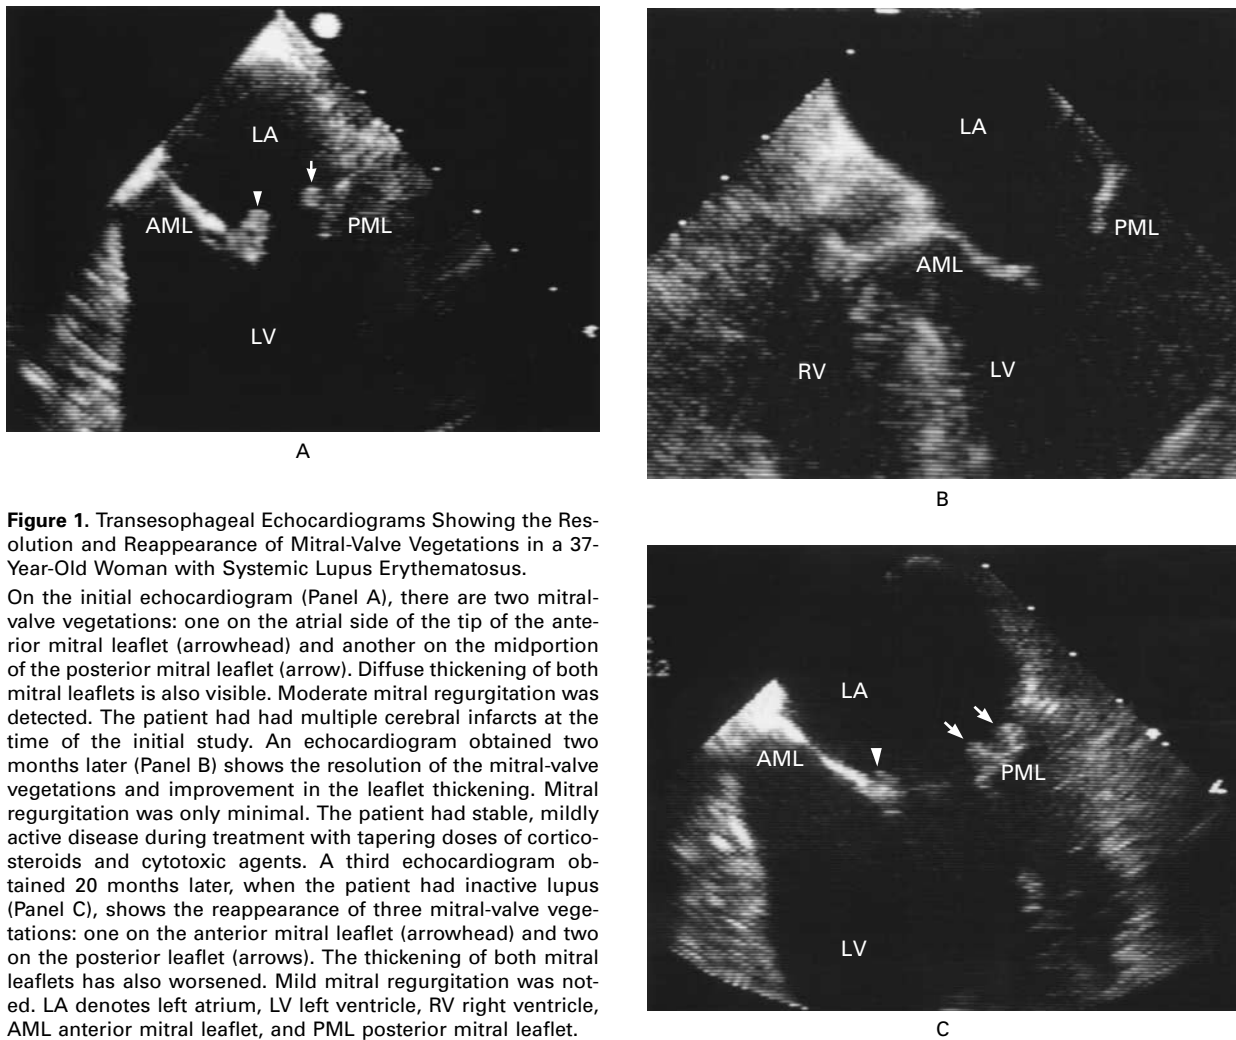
Transesophageal Echocardiograms Showing the Resolution and Reappearance of Mitral-Valve Vegetations in a 37-Year-Old Woman with Systemic Lupus Erythematosus.
